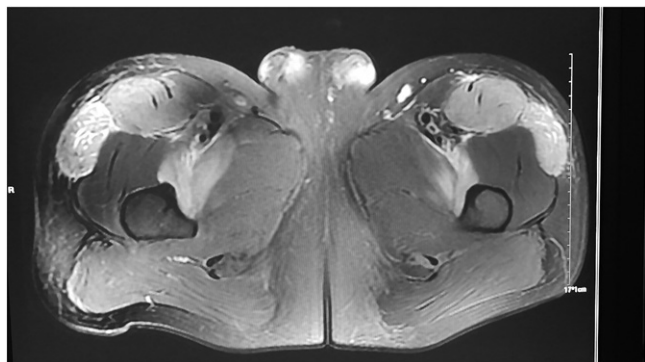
Magnetic resonance imaging (MRI) of hip, T2, and diffusion weighted image, transverse section.
